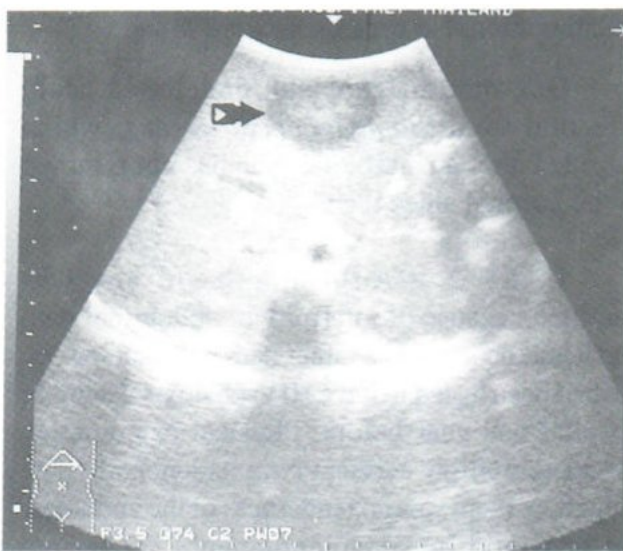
Transverse sonogram shows a "target" lesion (arrow) in left liver lobe.
